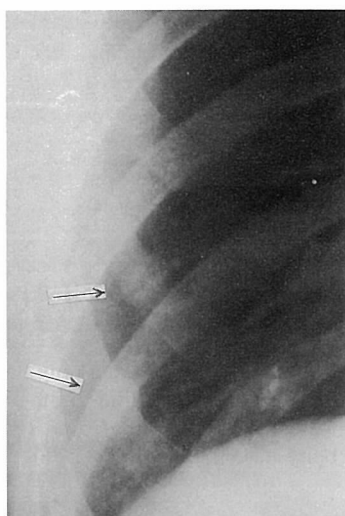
Follow up chest radiography 2 months later showed callus formations of the right Vth and VIth ribs (→).
